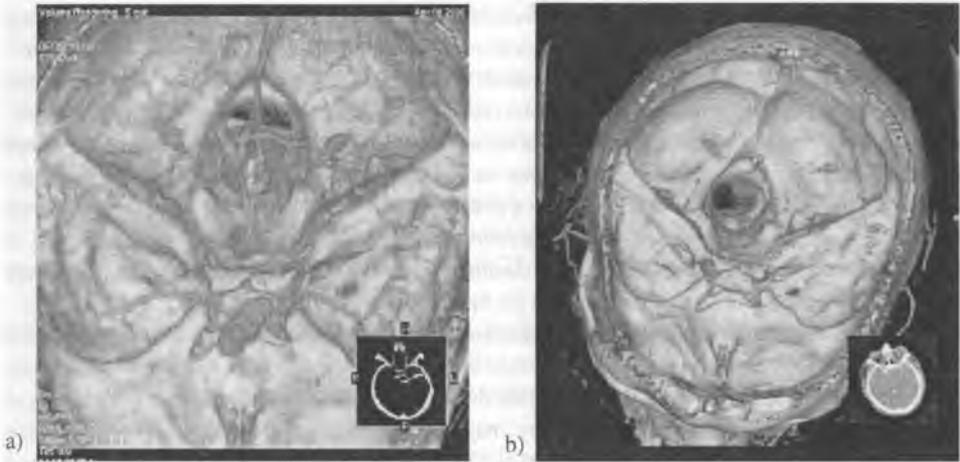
CTA – 3D volume rendering projections. The patient with anterior communicating artery aneurysm. All arteries are opacified (a). After three days: the examination of the same patient suspected of brain death. No enhancement of the intracranial vessels (b)
